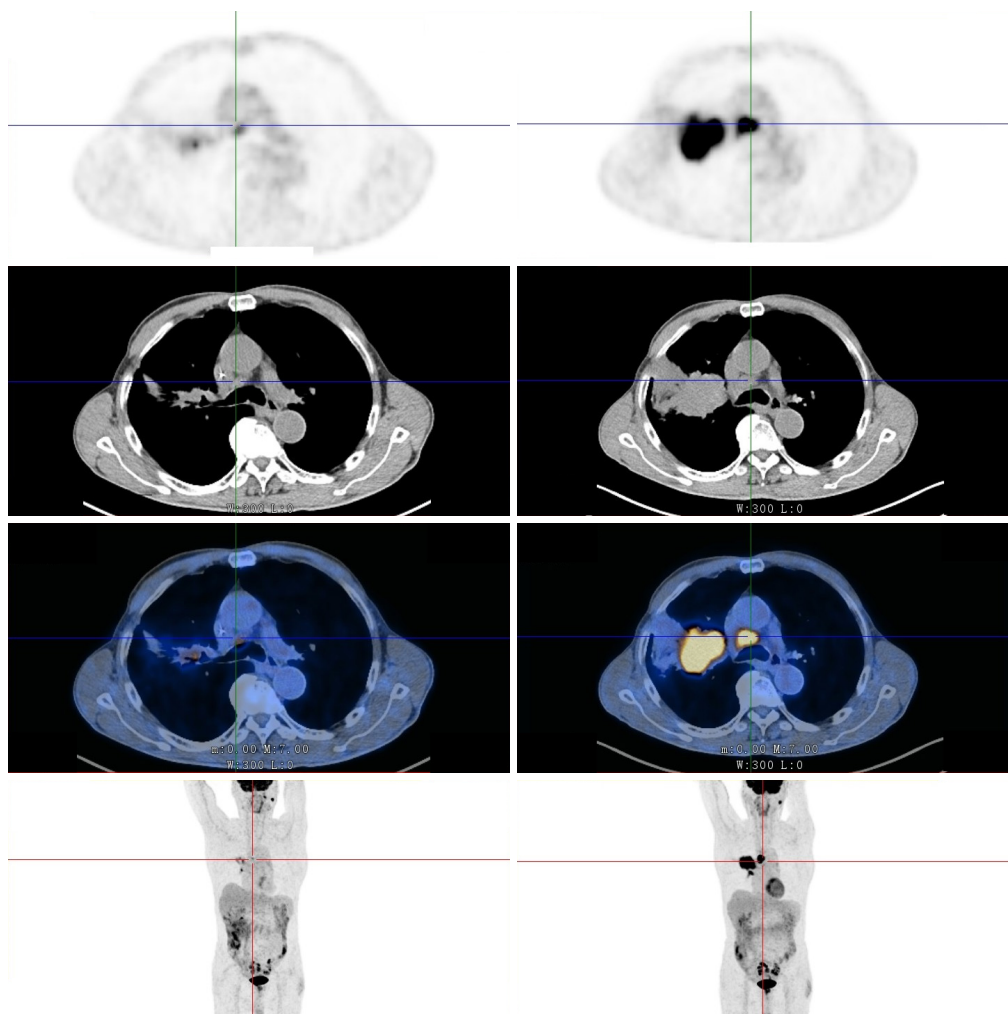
Comparison of PET-CT before and after neoadjuvant treatment in a patient: preoperative PET-CT on the right, showing central lung cancer with atelectasis in the right lung and mediastinal lymph node metastasis; PET-CT on the left after two cycles of neoadjuvant immunotherapy and chemotherapy, showing a significant reduction in the tumor and mediastinal lymph nodes, and a significant reduction in FDG metabolism. PET-CT, positron emission tomography-computed tomography; FDG, fluorodeoxyglucose.
